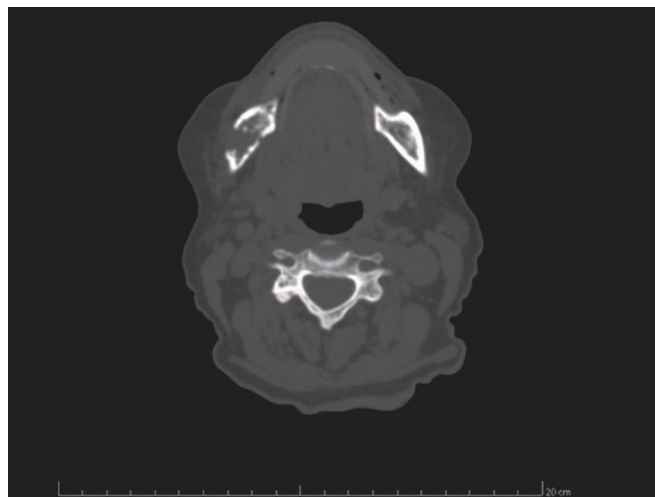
CT Scan - Transversal section: right posterior region of the mandible with cortical bone loss.
